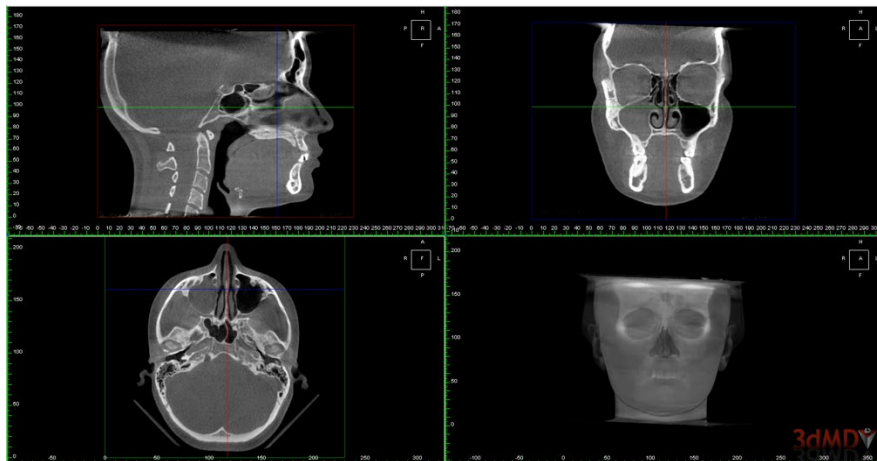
Determination of Orbitale on CBCT
